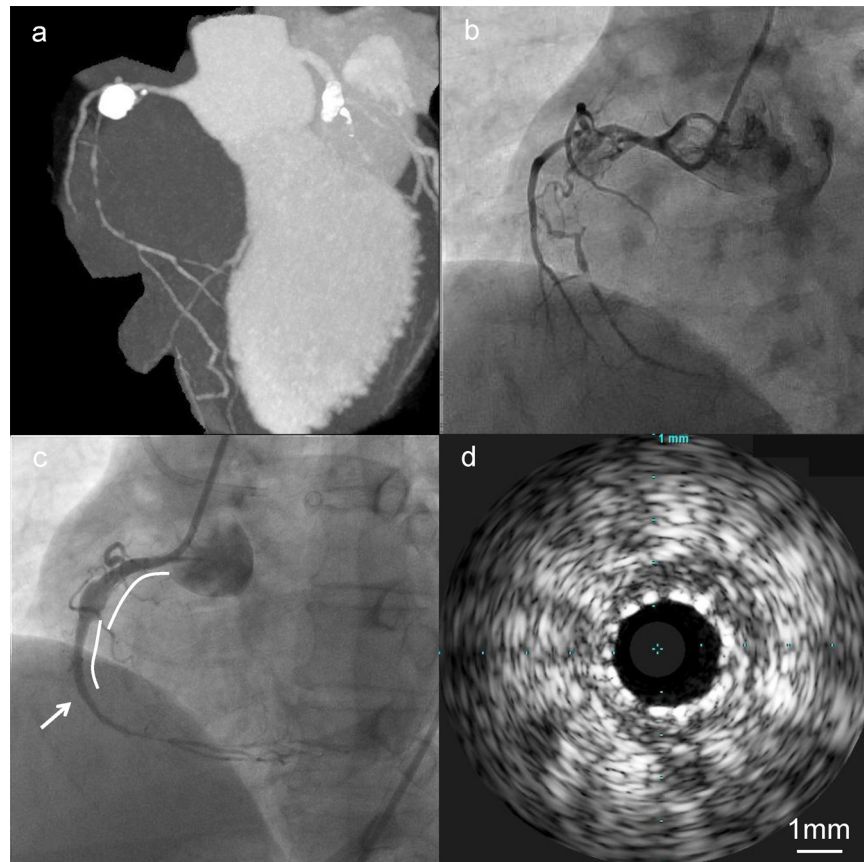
(a and b) 320-Detector computed tomography coronary angiography and coronary angiography showed chronic total occlusion of the right coronary artery and a coronary aneurysm with calcification. (c) Coronary angiography after zotarolimus-eluting stents implantation (proximal, 3.5 mm × 24 mm; distal, 2.5 mm × 24 mm, white lines). (d) Intravascular ultrasound at site of arrow in (c) indicating stent distal edge showed good expansion and apposition of the stent.
